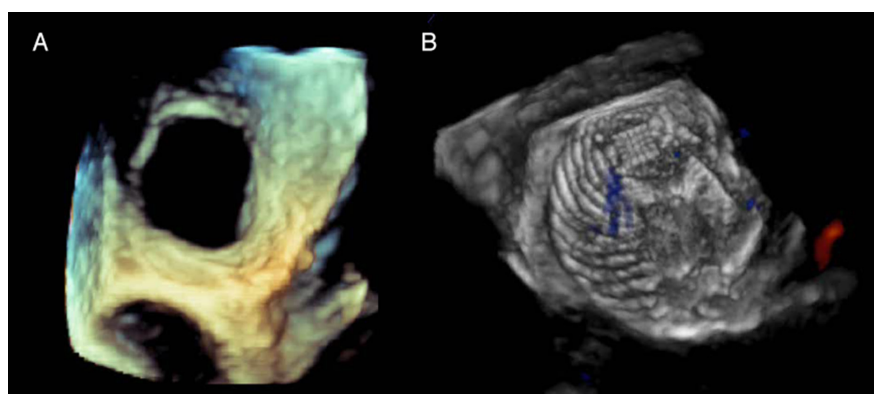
3D transesophageal echocardiography visualization of atrial septal defects (A); same lesion after deployment of Amplatzer device (B)
